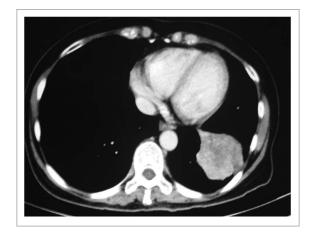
Pre-regimen CT chest, left lower lobe lesion 3 by 3 cm.
